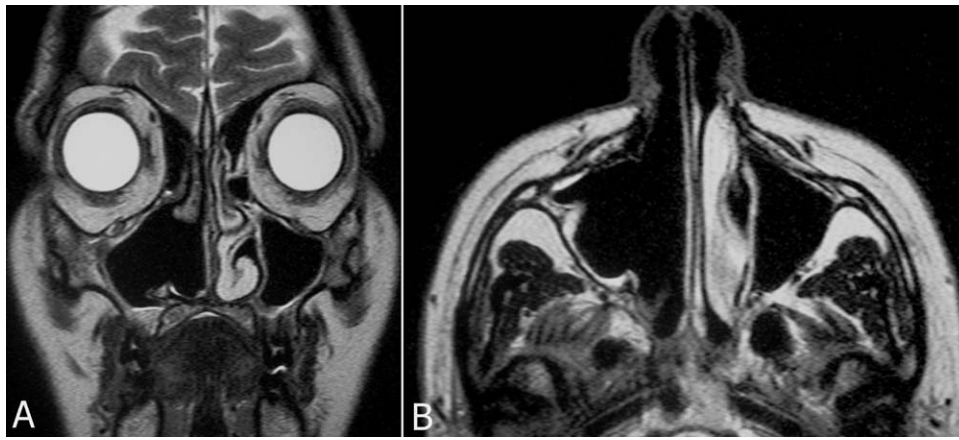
MRI SE T2 on coronal (A) and axial (B) planes. Follow-up MRI performed 42 months after surgery shows no sign of recurrence.
